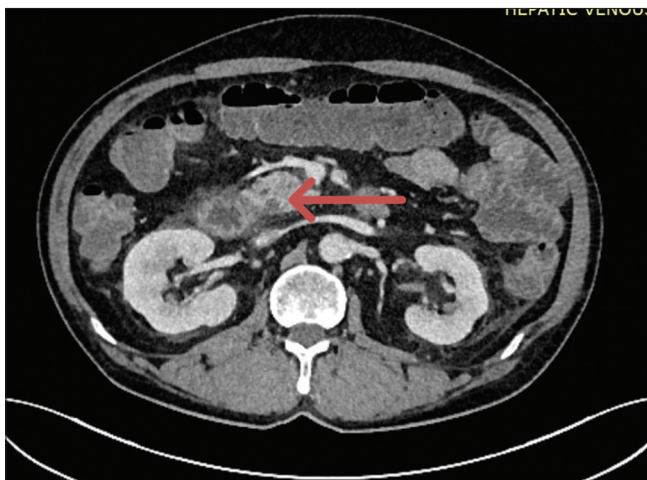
CT abdomen showing edematous groove, thickening of the second and third part of the duodenum, and surrounding fat stranding
